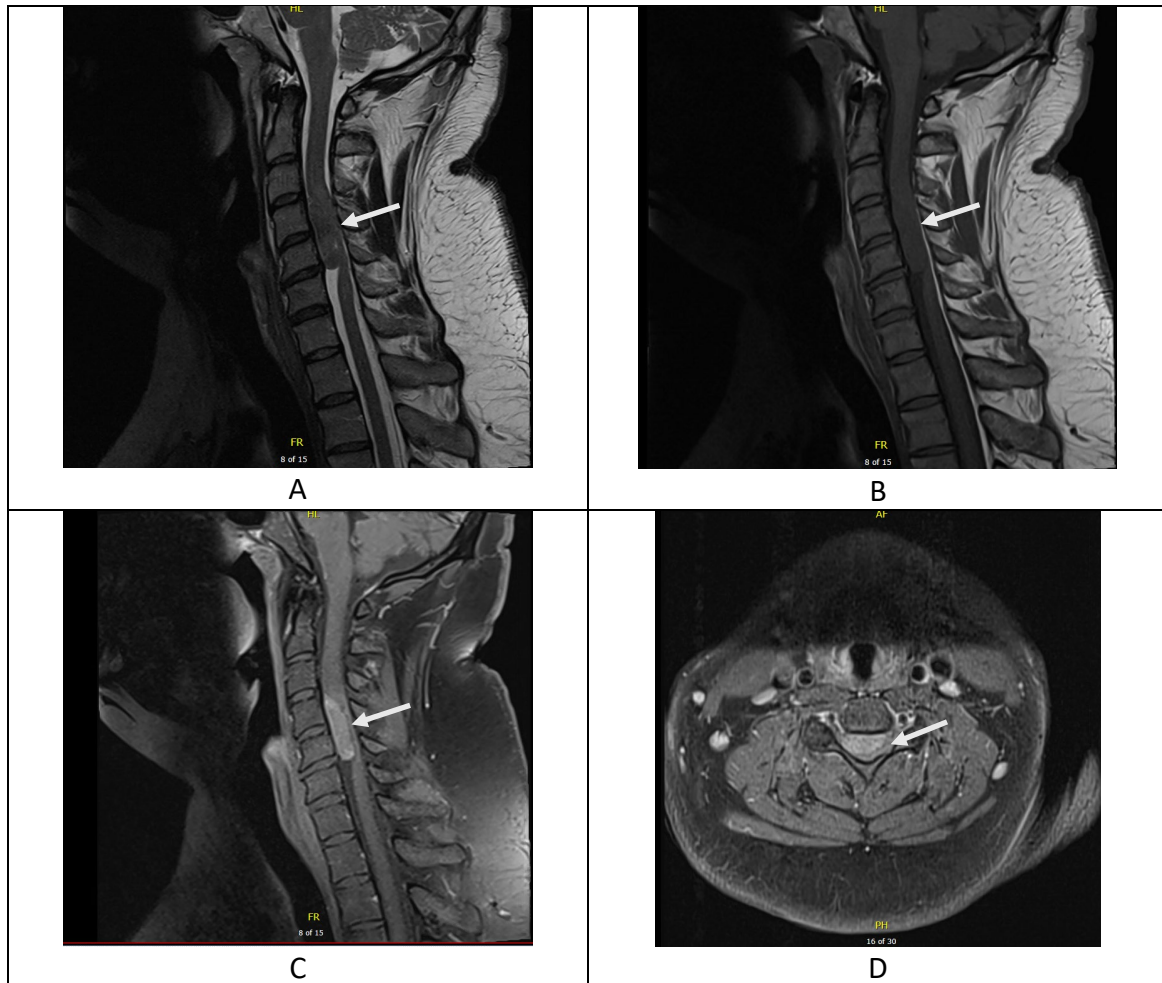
(A) T2-weighted and (B) T1-weighted mid-sagittal MRI images of the cervical spine showing an intradural extramedullary lesion extending from C4 to C5–C6 disc space and appearing isointense to the spinal cord. (C) Post-gadolinium MRI demonstrating homogeneous enhancement of the lesion, with near-complete effacement of the spinal canal and central cord compression, as shown on the corresponding axial image (D).
